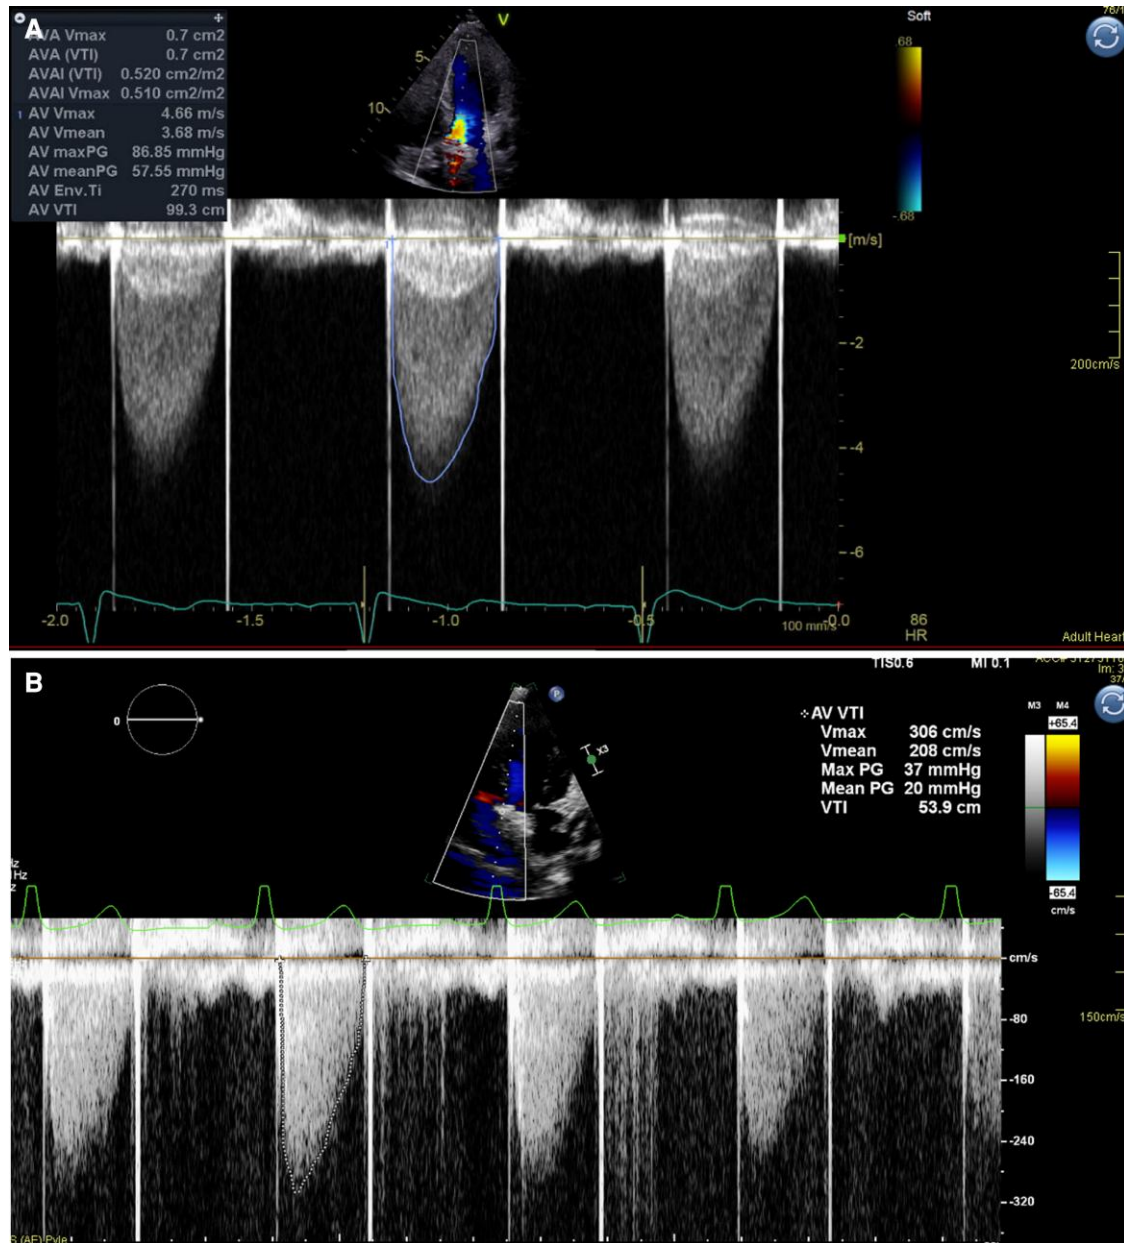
(A) Valve gradients on transthoracic echocardiography pre-thrombolytic therapy. Initial echo showing a peak and mean gradient of 87 and 58 mmHg, respectively, across the mechanical aortic valve in apical five-chamber view. (B) Valve gradients on transthoracic echocardiography post-thrombolytic therapy. Repeat echo after 5 sessions of low-dose ultra-slow infusion of tissue plasminogen activator showing decrease in the peak and mean gradients to 37 and 20 mmHg, respectively, across the mechanical aortic valve.
